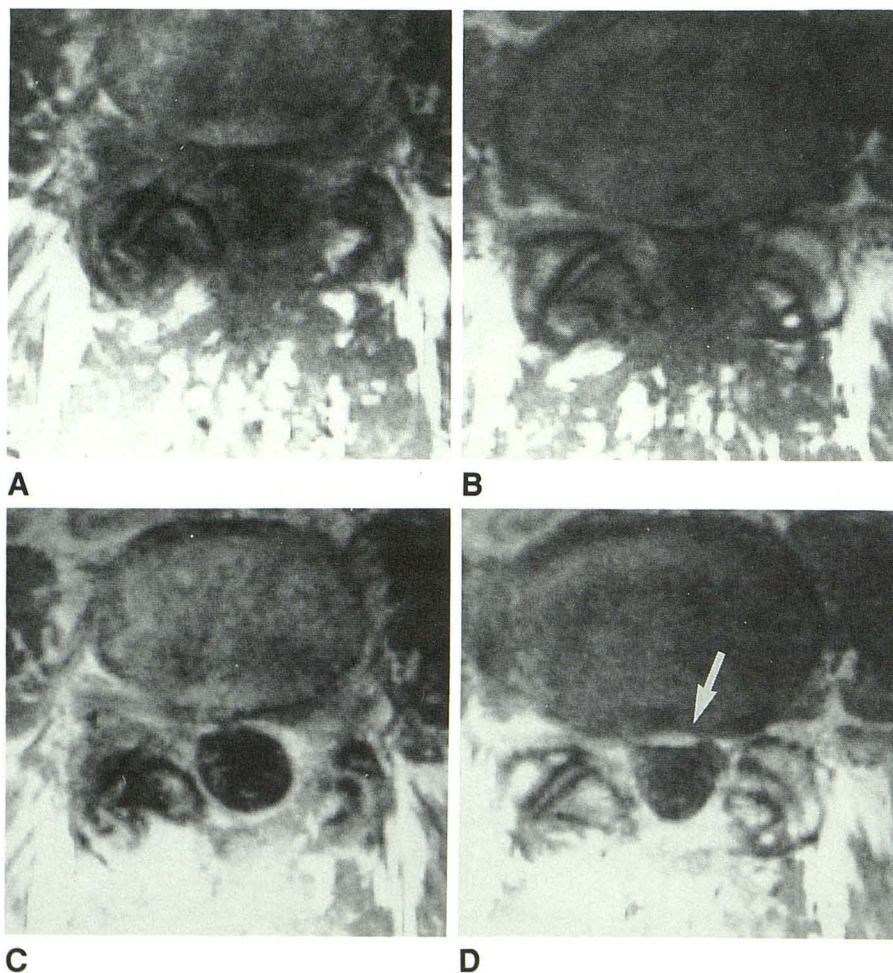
A and B, Axial T1-weighted (500/17) precontrast MR images show extensive epidural soft tissue circumferentially around the thecal sac, with a bulging intervertebral disk.
